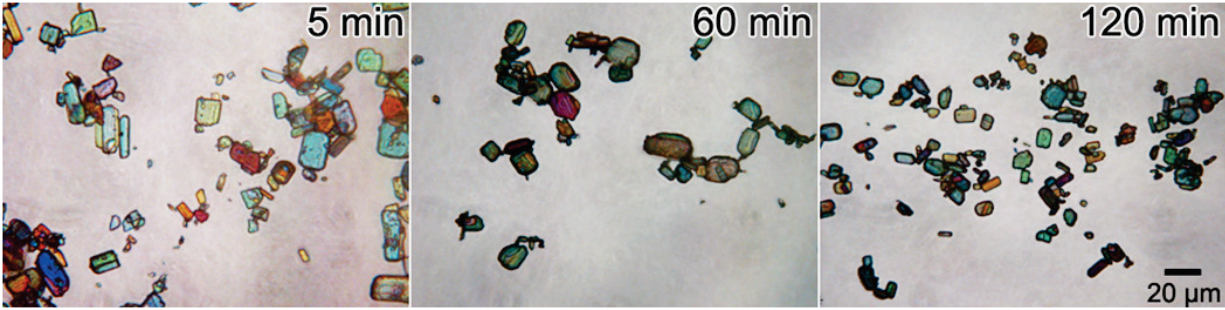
Sonofragmentation. Breakage of sonocrystallized aspirin particles at 10 W and variable exposure time. Sonication performed with a 50% duty cycle (10 sec on, 10 sec off). Times are listed as total time exposed to ultrasound (i.e., a “5 minute” experiment takes 10 minutes but the horn was energized for only five of those minutes). All images are on the same scale.
